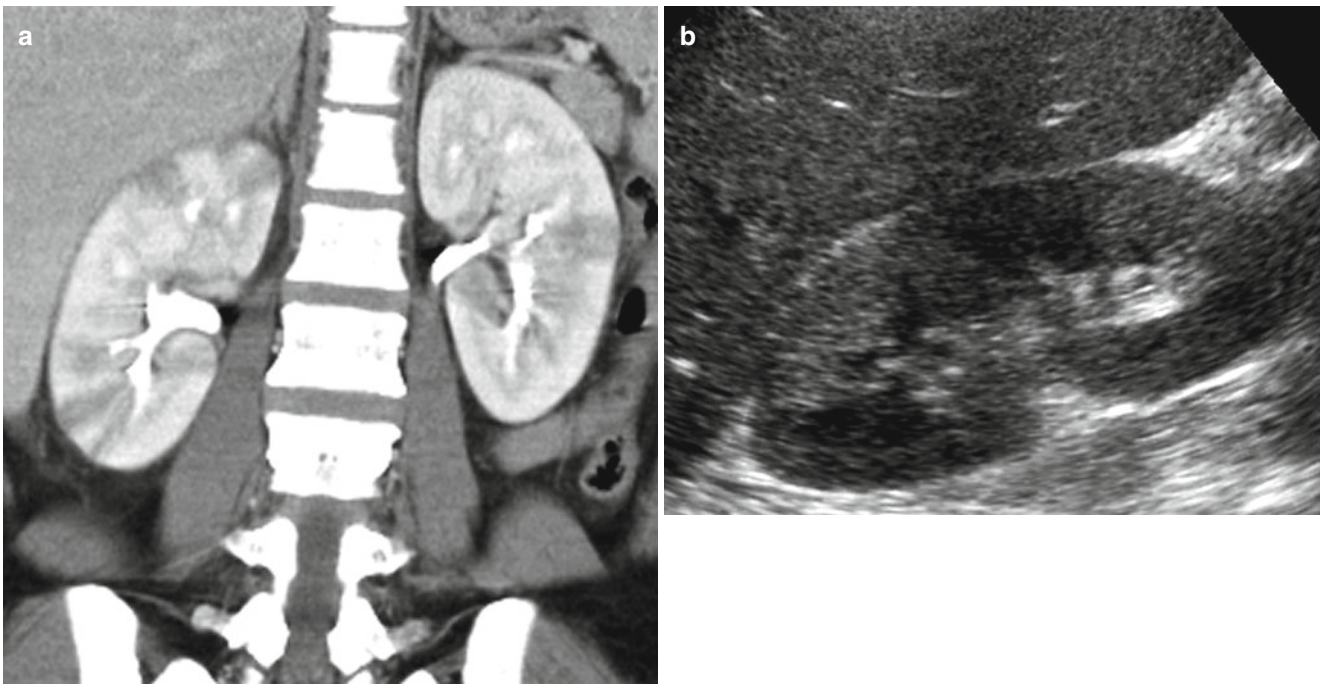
Acute bilateral pyelonephritis in a 34-year-old female with fever, chills, and right upper quadrant pain. (a) Contrast-enhanced coronal CT image demonstrates bilateral, right greater than left, striated
